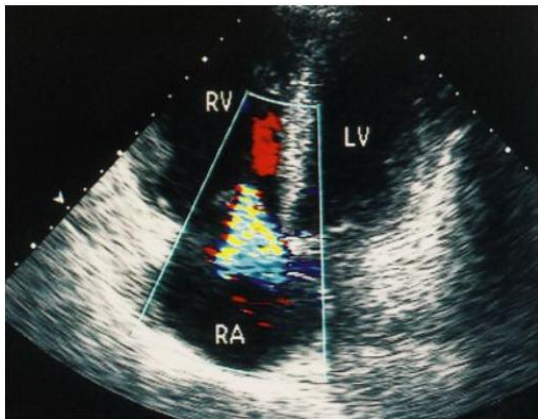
Shows color Doppler examination showing TR
